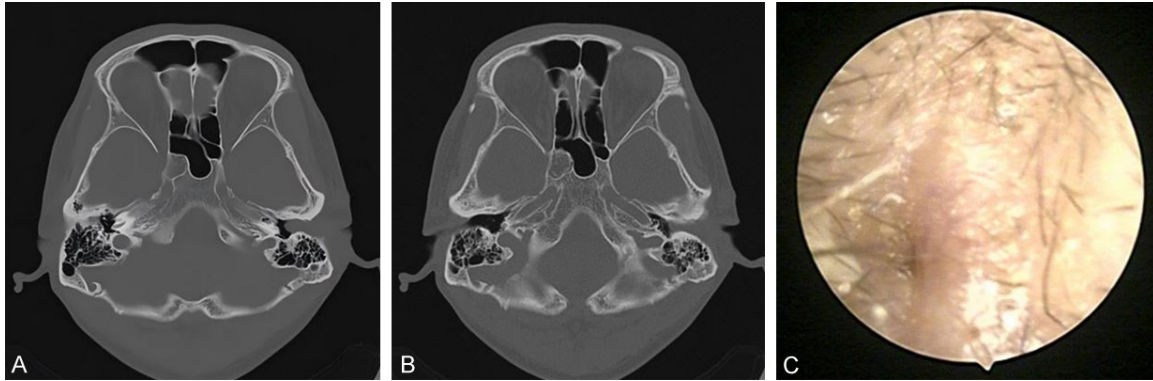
Imaging and endoscopic findings of the left external auditory canal (EAC). A: Temporal bone CT shows a soft-tissue density shadow within the left EAC. B: Temporal bone CT shows soft-tissue density obstructing the left EAC. C: Otoendoscopic view reveals a pinpoint-like narrowing of the left EAC. Note: CT: computed tomography.
